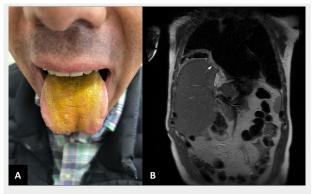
A) At the clinical examination, the tongue takes on a dark yellow colour. B) Magnetic resonance imaging revealed a bronchobiliary fistula (arrow)
